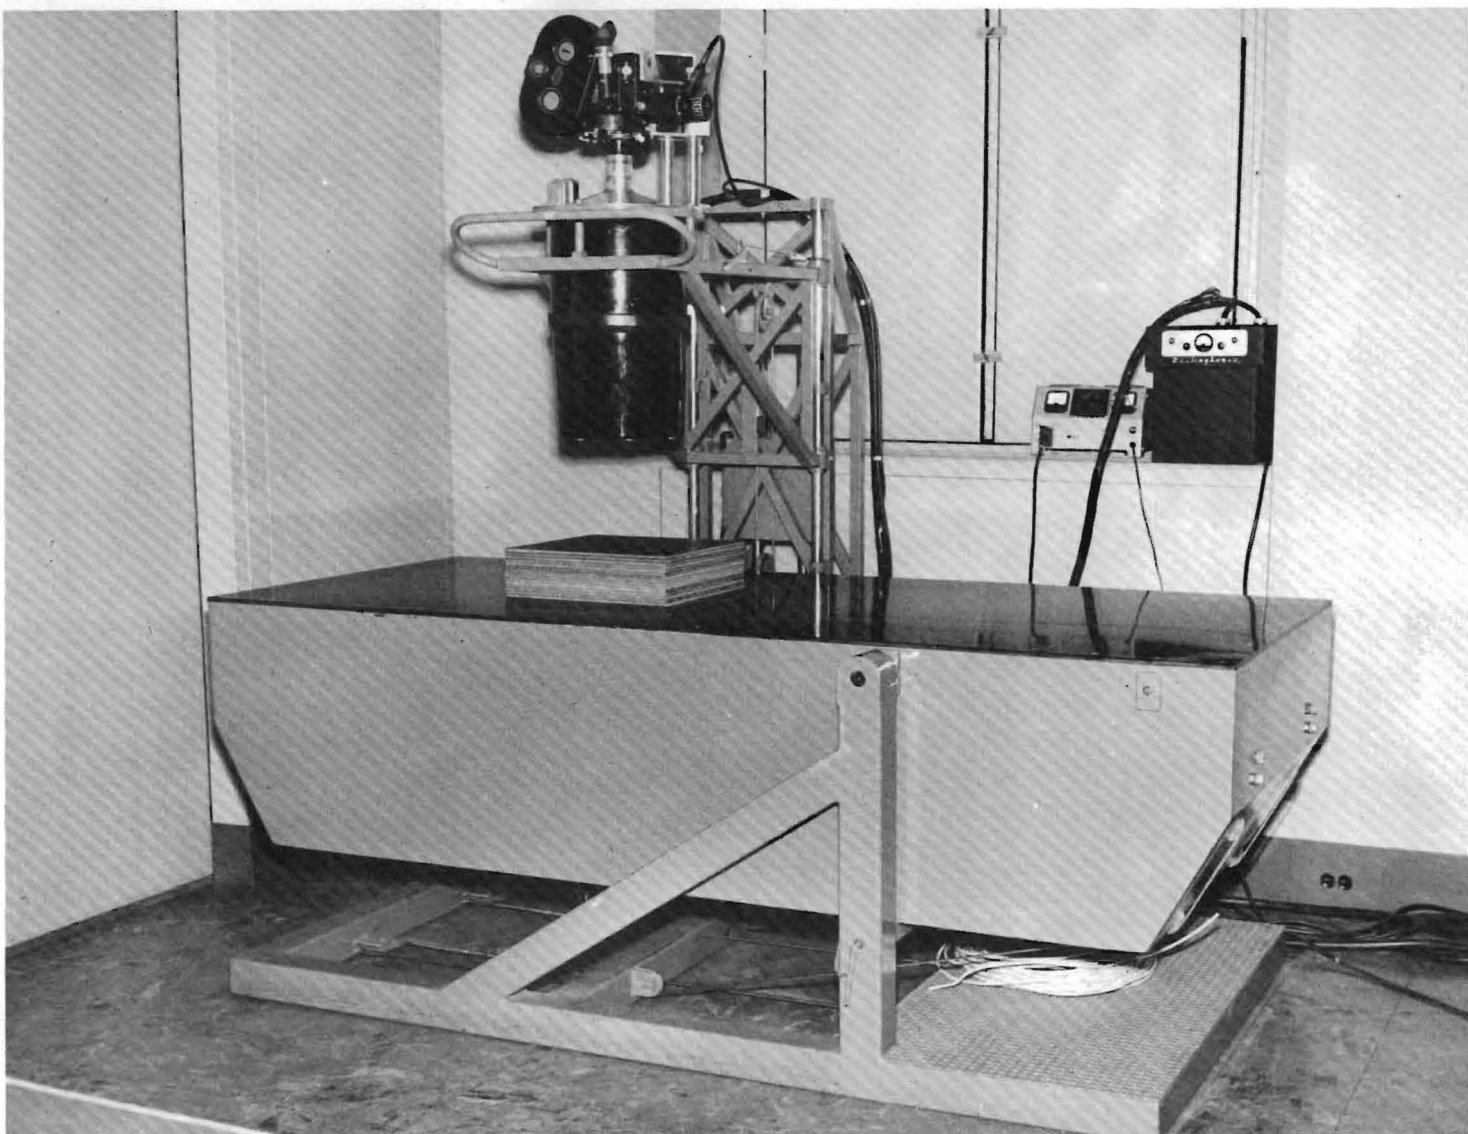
View of Special X-ray Table in a Horizontal Position.
